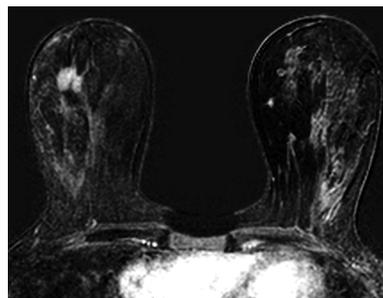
Subtracted THRIVE contrast enhanced MR image showing a triple negative breast cancer of the right breast in a 49-year-old woman with marked BPE evaluated in the contralateral breast.
